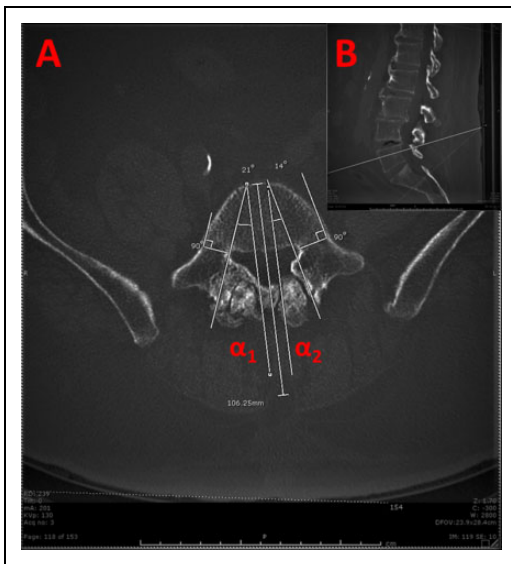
Axial (A) and sagittal (B) views from computed tomography scan demonstrating transverse pedicle angle (TPA) measurement. TPA was calculated as $(\alpha_1 + \alpha_2)/2$ for vertebral levels L3-L5. Axial slices through the widest portion of the pedicle in the cranial-caudal direction were used for measurements.
